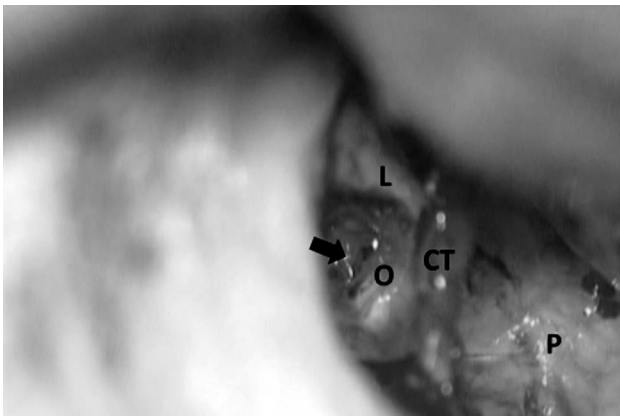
Intraoperative view of the defective stapes footplate. CT: Chorda tympani; L: Long process of the incus; O: Oval window; P: Promontory; Black arrow defective stapes footplate.
